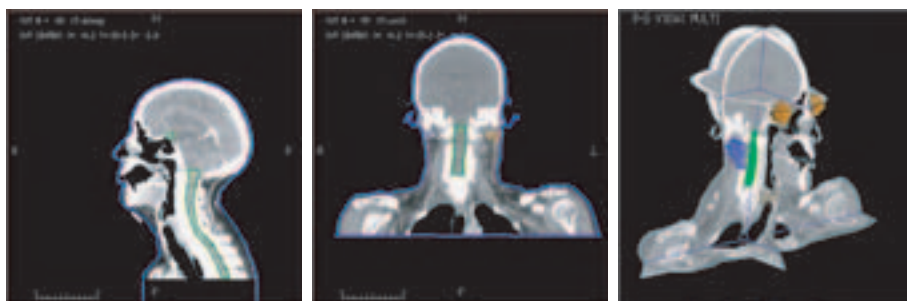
Displays of sagittal, coronal and multiplanar CT information.
